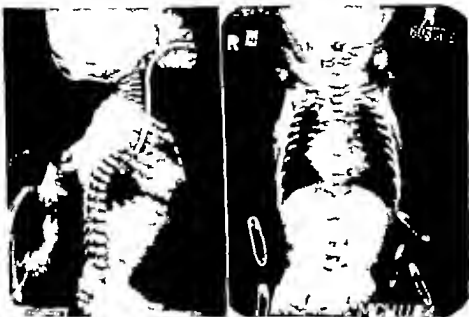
(Case D B) — 1. X-ray taken the day prior to admission showing the air-filled upper esophageal pouch. 2. The posterior (prior film taken on the day of admission) reveals the prominence of the right atrium — the continued beams of air in the stomach.
